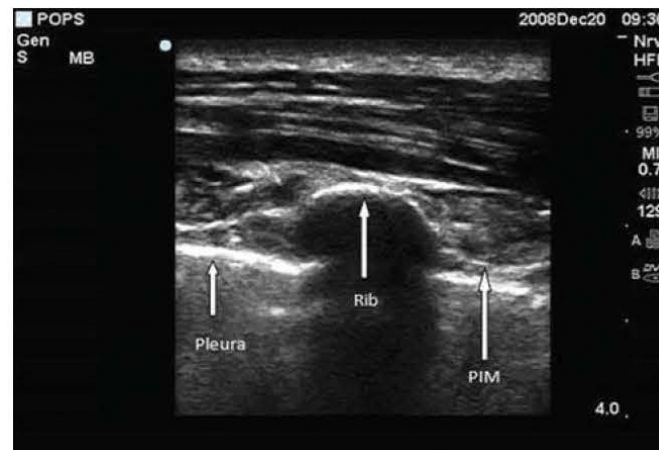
Ultrasound scan of the chest wall showing the rib, pleura and PIM (Karmakar, 2001).
